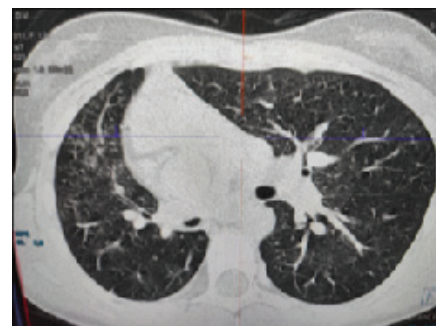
Computed tomography of the chest. Thickening of the walls of the distal bronchi on the right; parietal substrate in the lumen of large bronchi and trachea; multiple centrilobular nodules and Y-shaped structures with the formation of a "tree-in-bud" pattern
